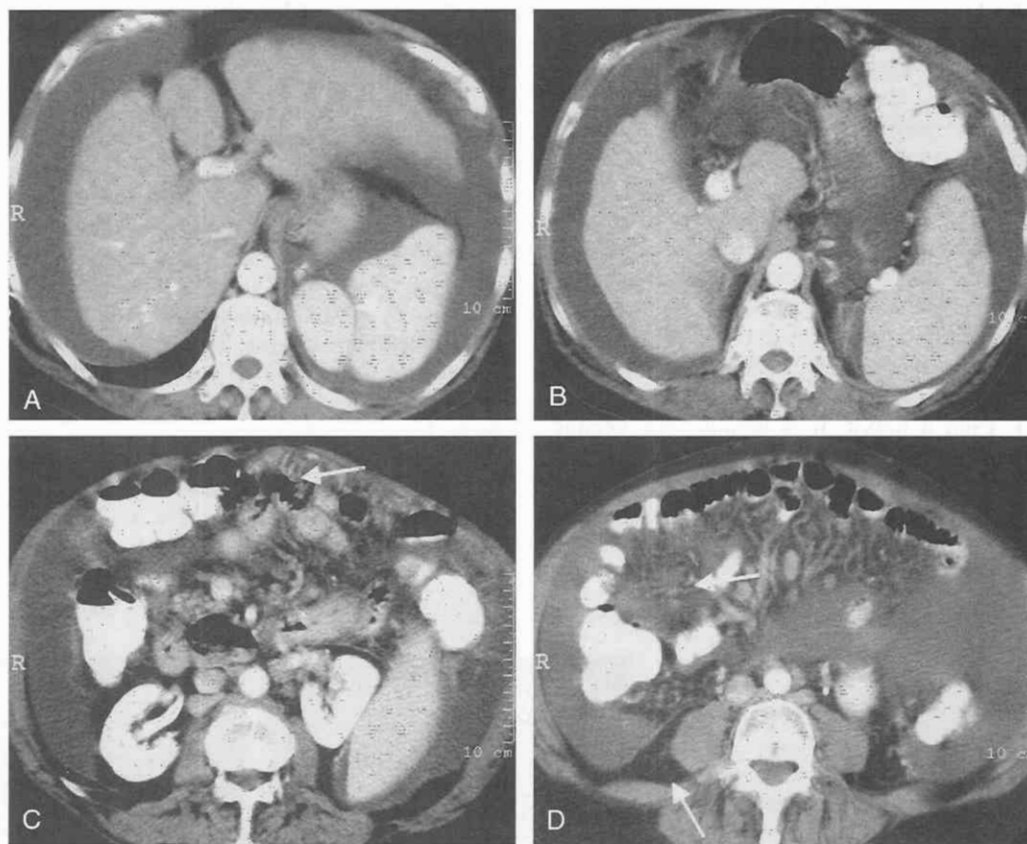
Cirrhosis of the liver secondary to alcohol abuse in a 68-year-old man. *A* and *B*, Contrast-enhanced CT scans show hypertrophy of the caudate lobe and of segments II and III. Conversely, segments IV to VIII appear unusually small. Other signs of liver cirrhosis include splenomegaly and ascites. *C* and *D*, Abdominal scans show another typical secondary sign: edema in the greater omentum and of the mesentery and retroperitoneum (arrows).
